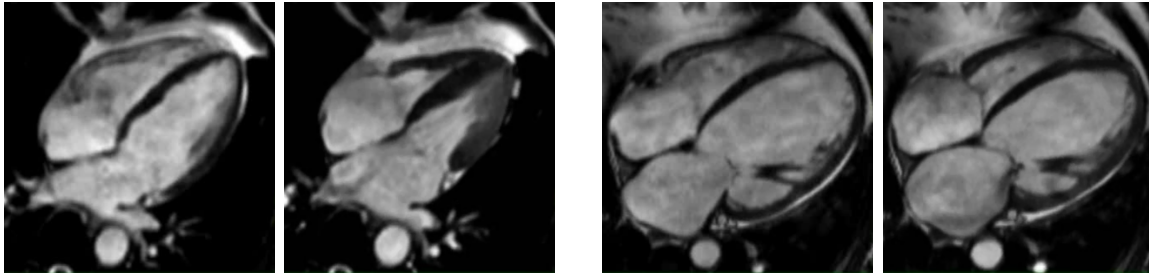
Four-chamber views of healthy heart on the left compared to a DCM heart with severely dilated left ventricle on the right as captured by cardiac magnetic resonance imaging (MRI). First and third image show hearts during diastolic phase, where the chambers are filled with blood (white), versus systolic phase (heart is fully contracted) in images two and four. Images courtesy of Siemens Healthineers.
